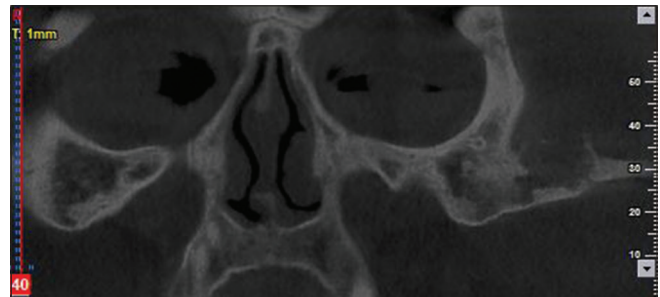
Computed tomography scan revealed osteolytic characteristic of the mass in the zygomatic bone that brought malignant process in the differentials
